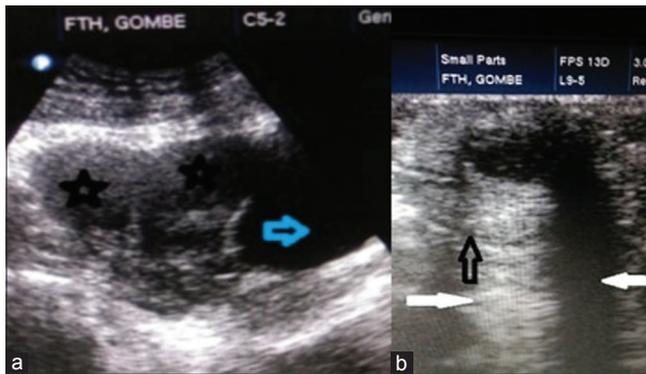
(a) Sagittal pelvic ultrasound scan of the uterus showing multiple well-defined hypoechoic rounded masses (black stars); (b) Superficial USS of the umbilical region demonstrated a well-defined rounded umbilical mass with heterogeneous echotexture (open arrows). Posterior acoustic shadowing and enhancement were both demonstrated (white arrows)
